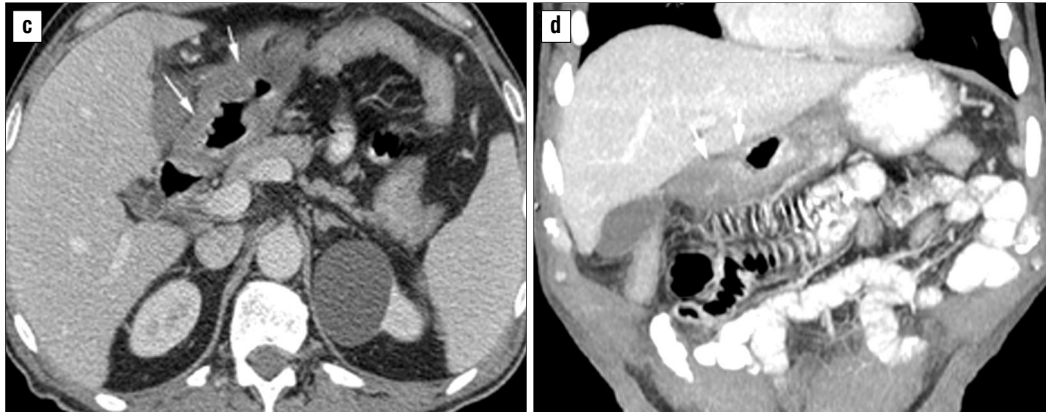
Enhanced CT evaluation (IInd examination- after treatment): disappearance of peritoneal, mediastinal and pancreatic region tumors with the persistence of a circumferential thickening of the horizontal gastric region walls (arrows).
